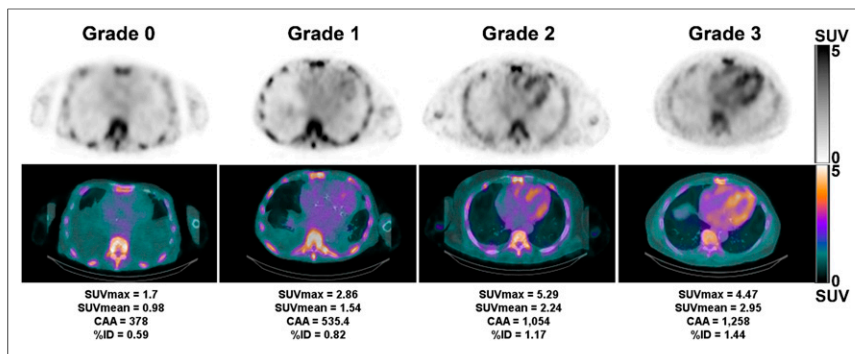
Representative ^{99m}Tc -pyrophosphate SPECT/CT images on SUV scale showing grades 0–3 uptake. Top row shows attenuation-corrected SPECT images, middle row shows SPECT/CT images, and bottom row shows corresponding SUV_{max} , SUV_{mean} , CAA, and %ID for each image.
